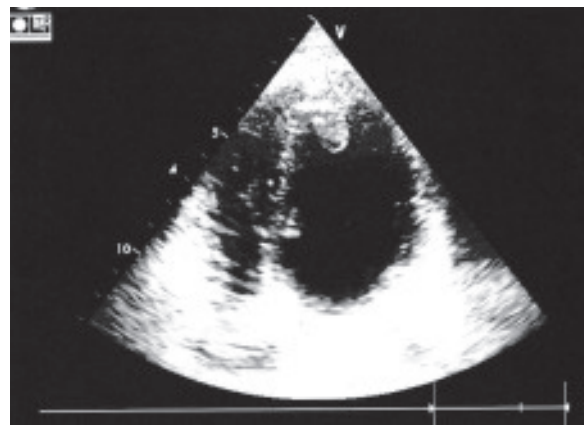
Follow up echocardiogram*
